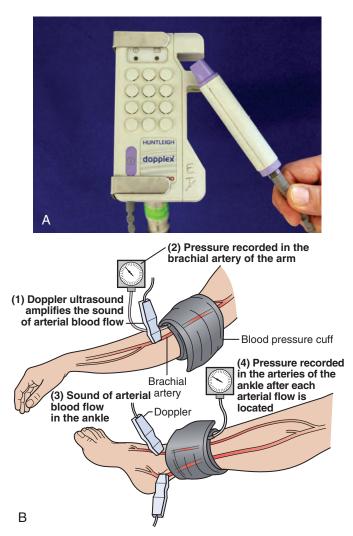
A, Handheld Doppler device with a speaker. Devices with an attached stethoscope are also used. B, Peripheral vascular testing is performed in a vascular laboratory, but an approximation of the integrity of the peripheral arterial circulation can be gleaned in the emergency department by using Doppler to determine systolic blood pressure in the foot and arm and calculate the ankle-brachial index.
